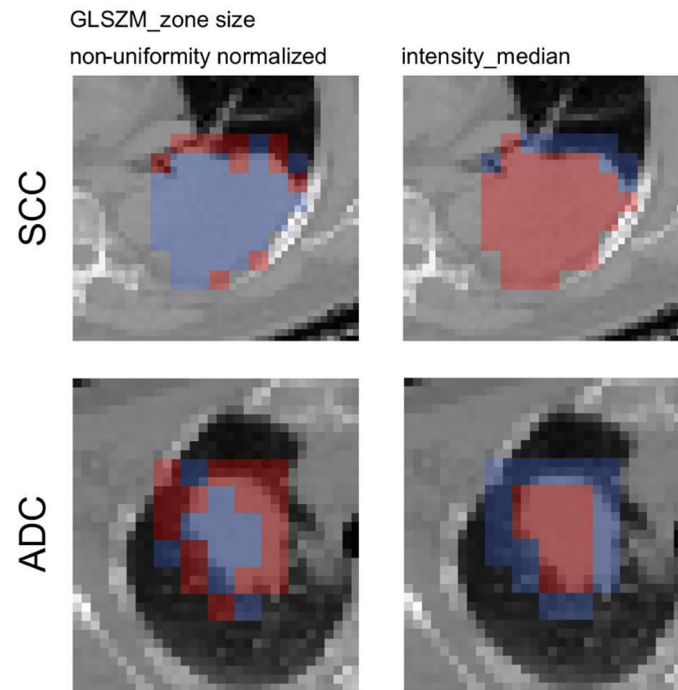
Axial slices of the feature activation maps overlaid with the corresponding CT scan of a squamous cell carcinoma patient (SCC) and an adenocarcinoma patient (ADC) from the validation cohort. Activated (red) patches had feature values larger than the median feature value from the training, whereas non-activated (blue) patches had feature values smaller than the median. The texture feature was activated mostly in the rim region whereas the intensity_median was activated mostly in the tumor region.
